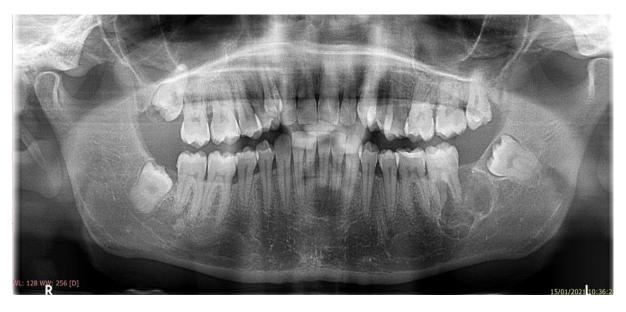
Radiographic Appearance.
